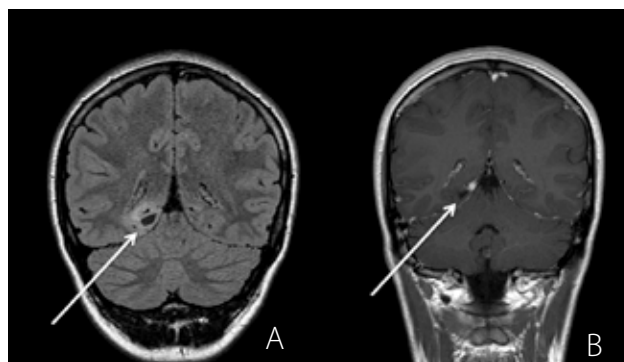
MR Brain Sagittal Images: FLAIR (A) and post-contrast T1 (B) weighted images demonstrating an enhancing mural nodule and small cystic component (arrow).
